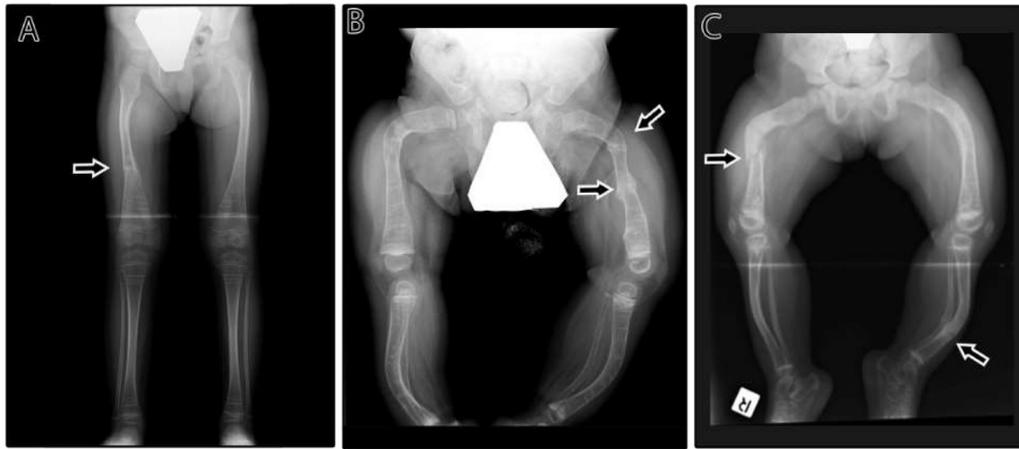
Lower extremity radiographs in children with OI caused by mutations in *COL1A1* or *COL1A2*. (A) Three-year-old girl with mild OI caused by a stop mutation in *COL1A1*. Straight lower extremities, and fracture of the right femur (arrow). (B) Two-year-old boy with severe OI caused by a glycine substitution in *COL1A1*. Deformities of all long bones and fractures of the left femur (arrow). (C) Five-year-old girl with moderate OI caused by a glycine substitution in *COL1A2*. Long-bone deformities and fractures of the right femur and left tibia and fibula (arrows).
